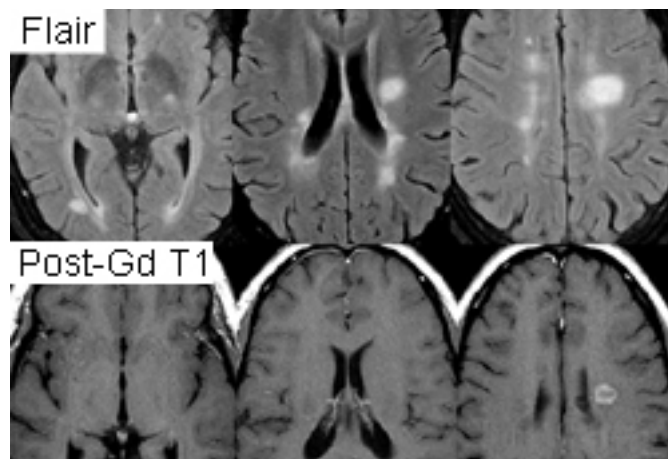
MRI using FLAIR and contrast agent gadolinium showing typical lesions seen in MS in the periventricular regions.
